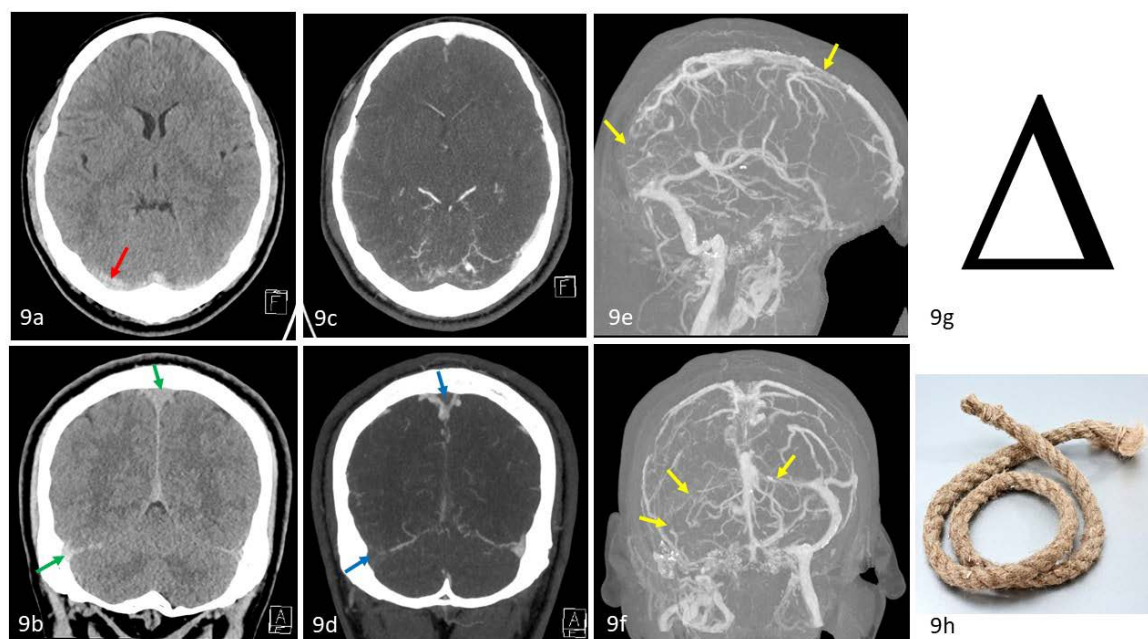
Cord sign and Empty delta sign. 36 year old male with dural venous sinus thrombosis. (9a) Axial unenhanced CT shows cord-like hyperattenuation seen along the right transverse sinus (red arrow) suggestive of the "cord sign" for dural venous sinus thrombosis. (9b) Coronal unenhanced CT shows hyperdense superior sagittal and right transverse sinuses (green arrows). (9c, 9d) Axial and coronal CT venogram shows central filling defects outlined by contrast in the superior sagittal sinus and right transverse sinus (blue arrows) demonstrating the "empty delta sign". (9e, 9f) CT venogram 3D volume-rendered reconstruction shows non-opacification of the posterior two-third of the superior sagittal sinus, proximal left and complete right transverse sinuses and right sigmoid sinus (yellow arrows). These are compatible with dural venous sinus thrombosis. Unenhanced CT: Siemens Somatom Force, Slice width 3.0 mm, 120 kV, 296 mAs; CT venogram: Siemens Somatom Force, Slice width 3.0 mm, 80 kV, 97 mAs, Intravenous contrast: 60 ml Omnipaque 350. (9g) Greek letter 'Δ' or delta. (9h) Image of a cord/rope.
